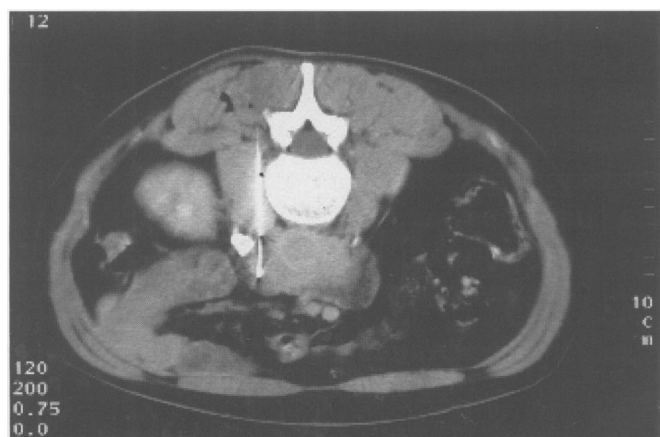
CT-guided biopsy with needle in mass.
